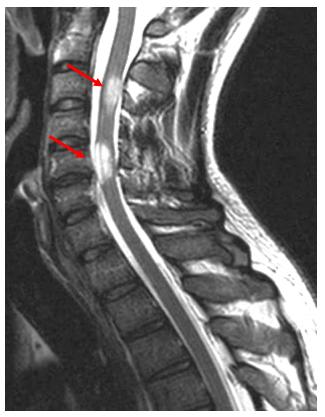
Sagittal T2-weighted image demonstrating two short segment high signal intensity lesions in the cervical spinal cord in MS
